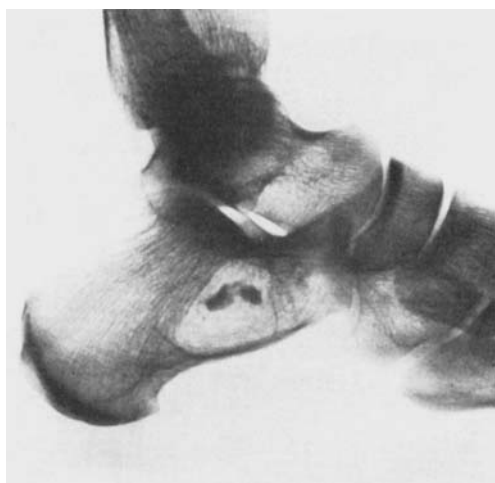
Lateral radiograph of left calcaneus. Note the sclerotic nidus in the center of the well circumscribed cyst.
